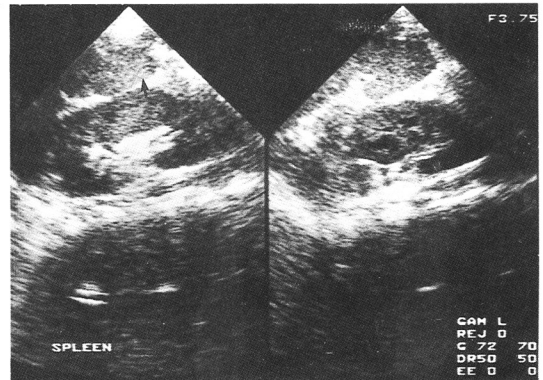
The lesion of splenic abscess is not seen in the abdominal ultrasound examination, 1 month later.
